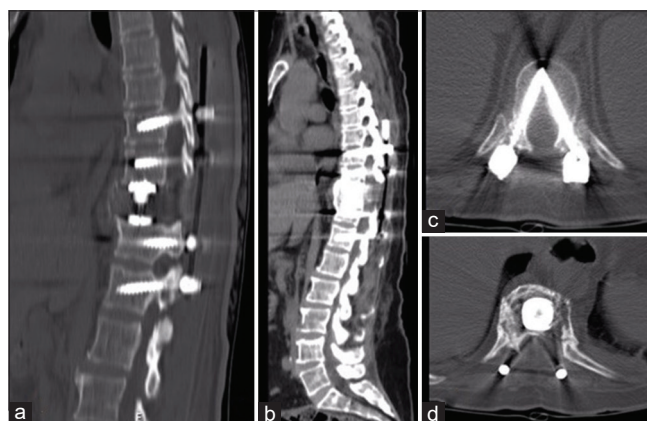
Postoperative computed tomography scans: At day 8 (a) and 2 years after surgery (b and c). Note the long-standing release of spinal cord compression and the significant correction of the kyphotic deformity. Significant decompression was achieved (D). The long construct 2-levels above and below the multiple myeloma lesion, the optimal convergence of percutaneous pedicle screws and the anterior column support afforded by the cylinder contributed to the long-term stability of the hardware construct
